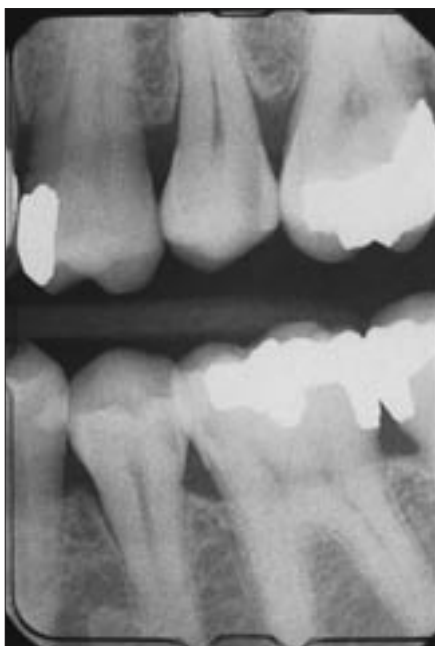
Preoperative radiograph indicates the need for facial slot Class II restoration in tooth 35 after placement of a conventional-approach mesio-occluso-distal amalgam restoration in tooth 36.
